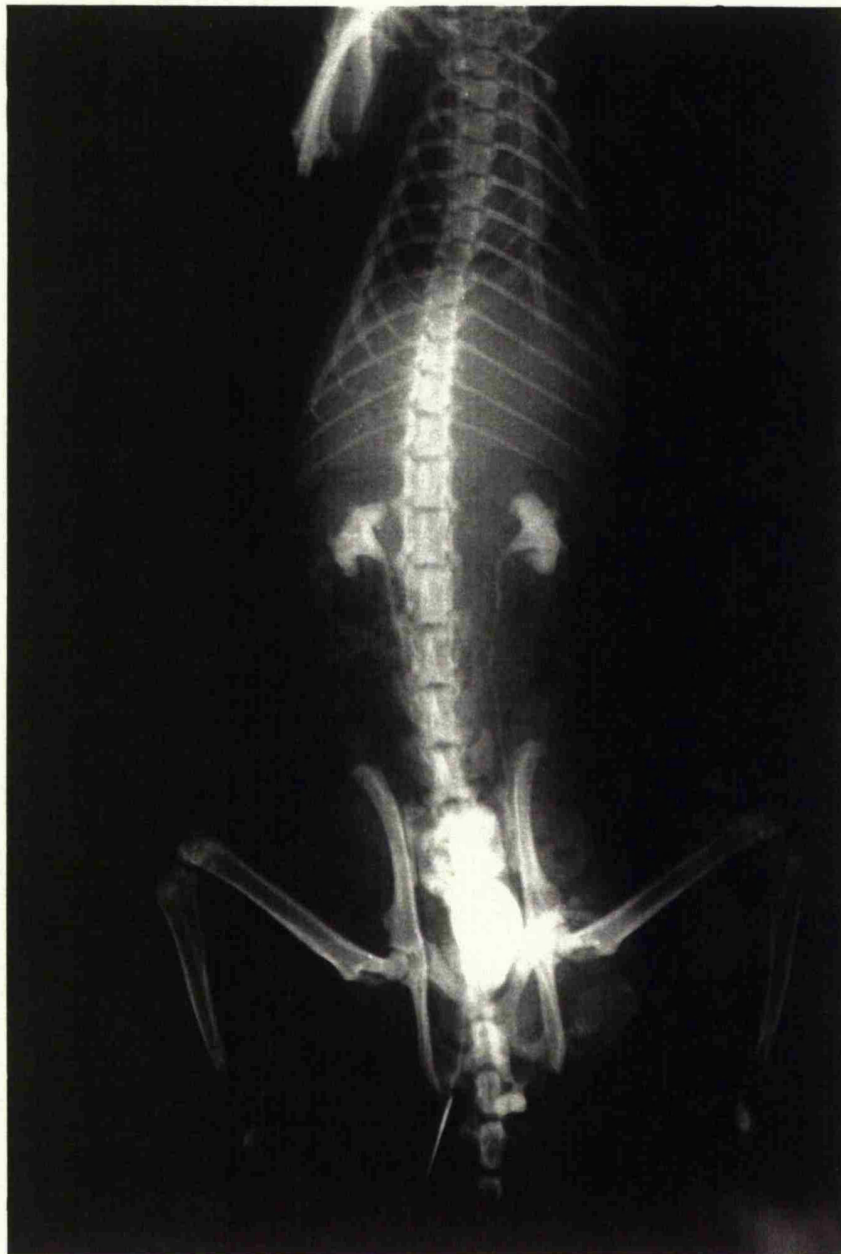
Xray of a vasogram demonstrating a patent right vas deferens, bladder full of contrast and incidental bilateral retrograde pyelograms
